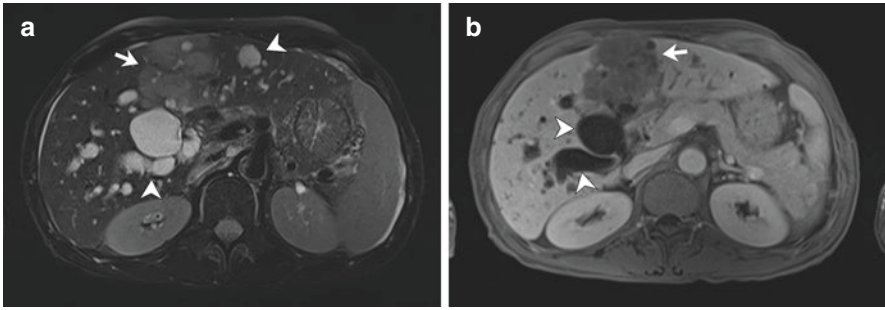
Magnetic resonance of a patient with Caroli's disease who developed an intrahepatic cholangiocarcinoma. T2-weighted (a) and T1-weighted (b) transverse images showing an irregular mass slightly hyperintense in T2, with poor and inhomogeneous contrast enhancement in T1 that turned out to be a cholangiocarcinoma (arrow). It compressed the biliary tree, causing dilation of the biliary tree, that coexisted with the dilation caused by CD
